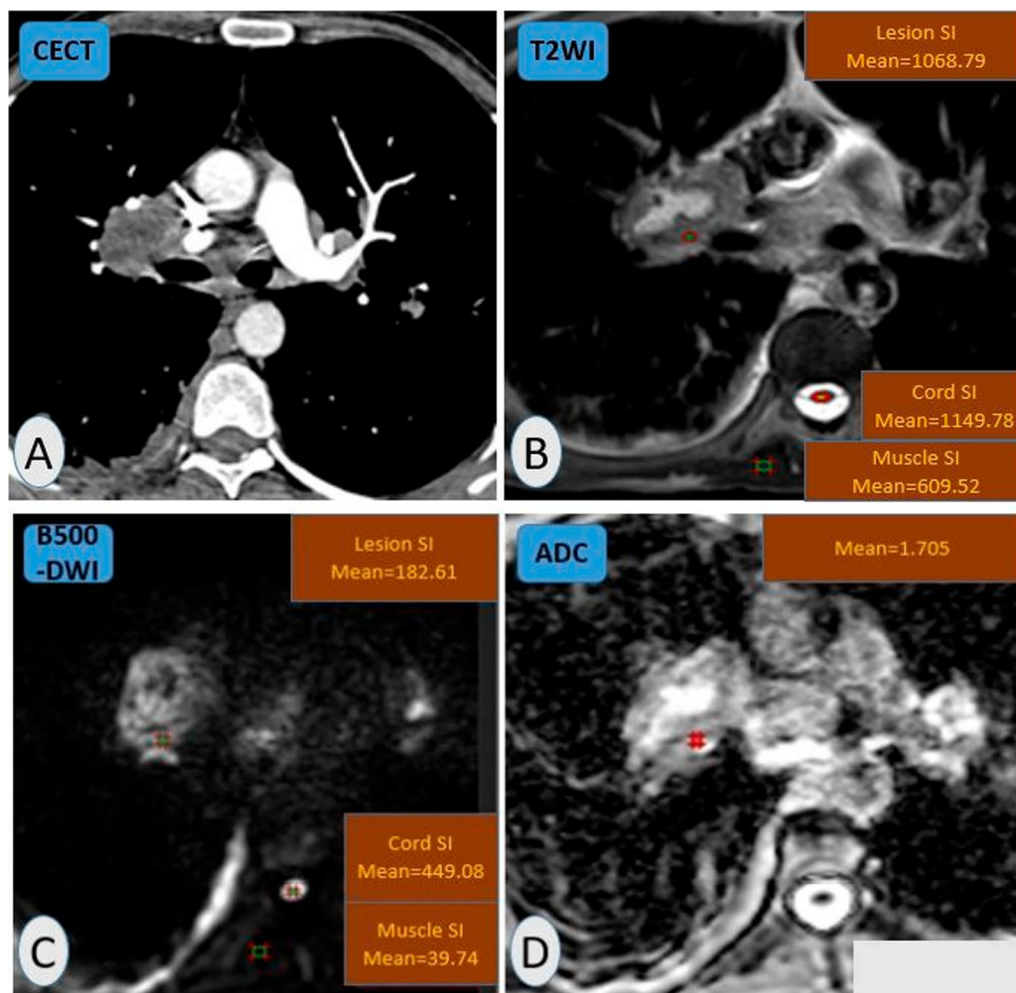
A 53 years-old-male patient complaining of progressive dyspnea, cough, night fever, night sweats, and weight loss. A Contrast-enhanced chest CT showed a right hilar globular lymph node with heterogeneous enhancement, necrosis, and breaking. B T2WI-MRI showed hyper-intense globular lymph nodes with lesion-to-cord signal ratio=0.9 and lesion-to-muscle signal ratio=1.7. C b500-DWI showed a mild bright signal with lesion-to-cord signal ratio=0.4 and relative contrast ratio=3.5. D Mean ADC value = $1.7 \times 10^{-3} \text{ mm}^2/\text{s}$ (no restriction) ... Pathologic proven necrotic TB lymph node
